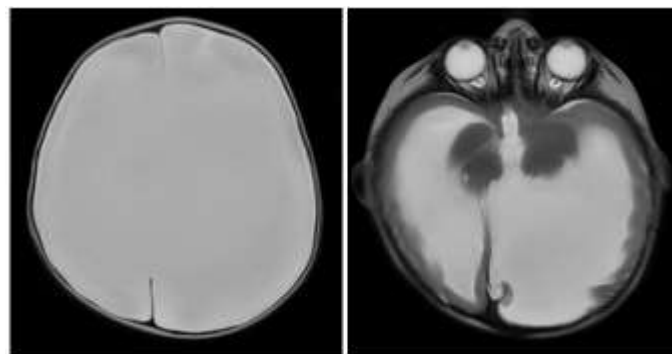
T2W MRI axial section shows presence of mid line falx.
